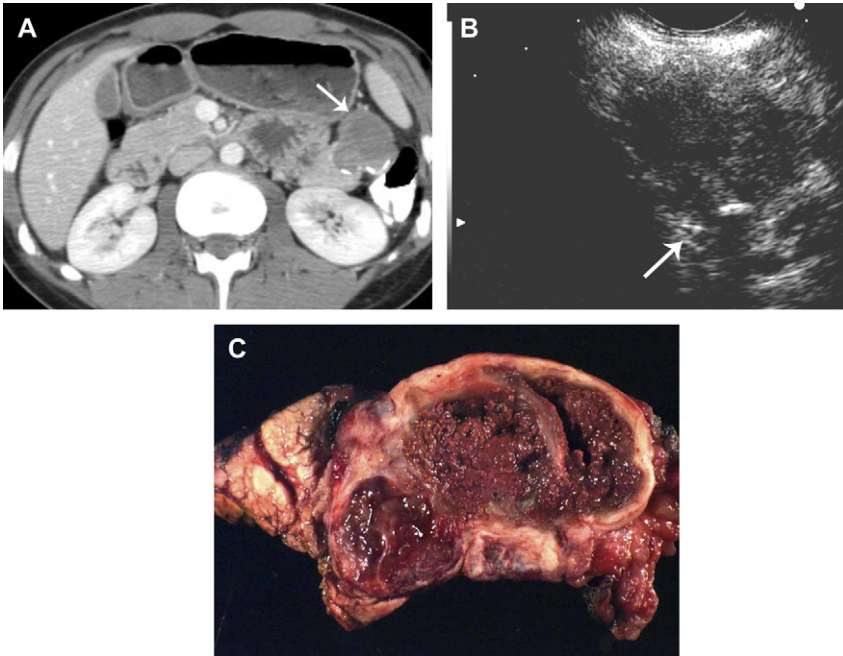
Twenty-two-year-old woman who has a solid and papillary epithelial neoplasm. (A) Contrast-enhanced CT shows a mass (*arrow*) arising from the pancreatic tail. Peripheral calcification and enhancing nodules are seen along with cystic or necrotic areas. (B) EUS shows a complex cystic mass with peripheral calcifications (*arrow*). (C) Photograph of resected mass shows an encapsulated tumor with foci of cystic necrosis and solid tumor.
